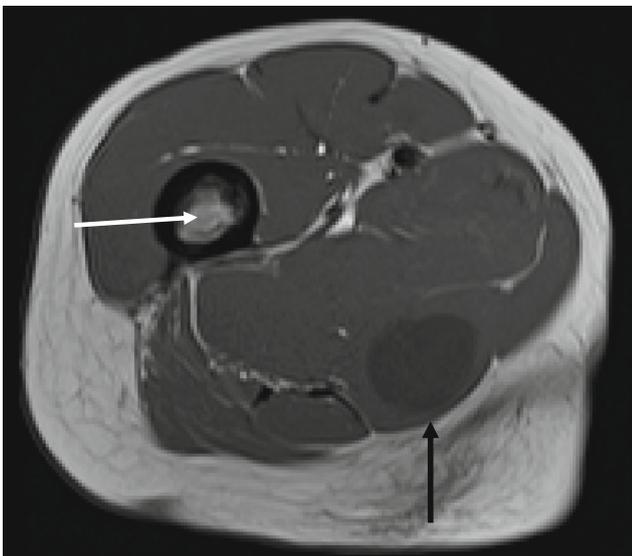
Axial T1-weighted MR image through the upper right thigh showing the low signal mass in the right adductor magnus (*black arrow*). Note is also made of subtle intramedullary signal abnormality in the right proximal femoral diaphysis (*arrows*)
